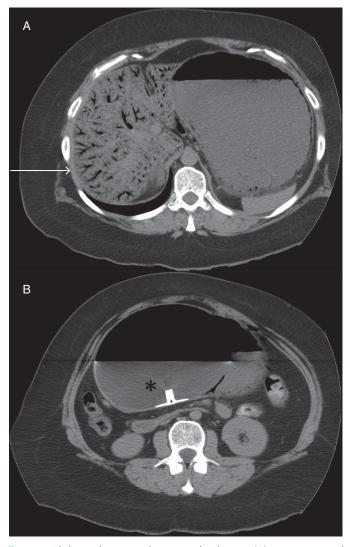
Abdominal computed tomography showing (A) extensive portal pneumatosis among all the liver segments (arrow) and (B) the intragastric balloon with radiolucent zone (asterisk) causing occlusion at the pyloric level and gastric wall pneumatosis.
